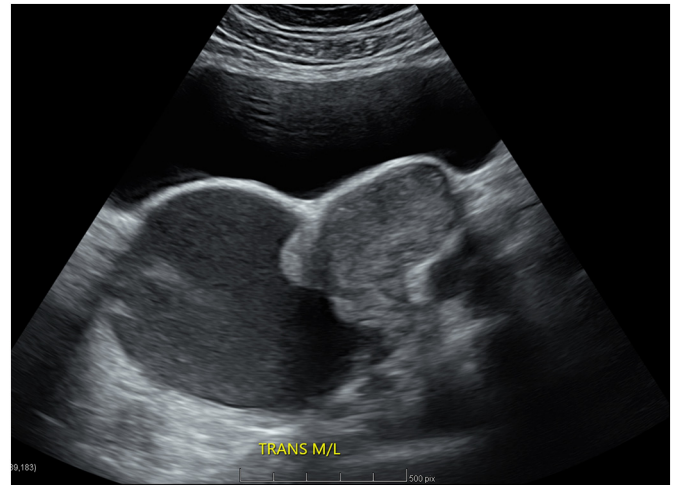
Ultrasound scan showing solid enhancing nodule adjacent to vagina and remnant cervix.
